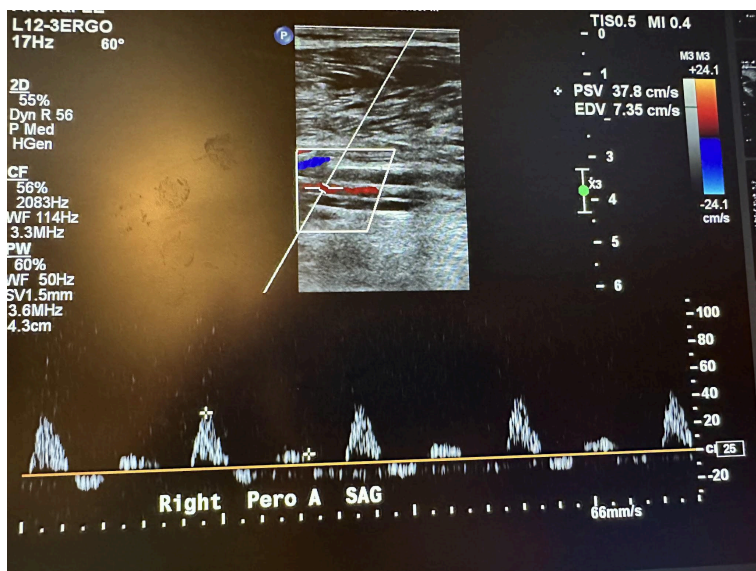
Sagittal image of the right peroneal artery with color Doppler and waveform analysis.
